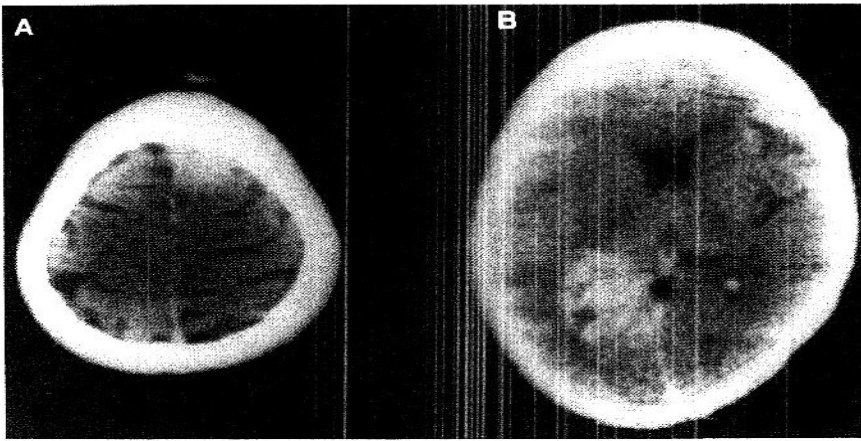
Contrast enhanced CT scan; A) right frontal parasagittal meningioma; B) left temporo-occipital glioma
